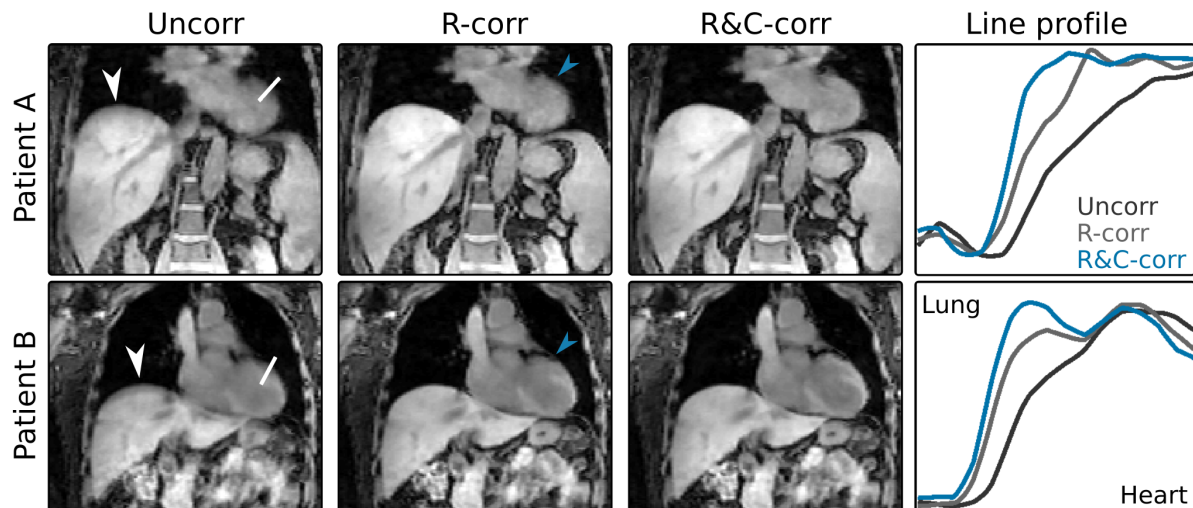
3D GRPE MR images reconstructed without motion correction (Uncorr), with respiratory motion correction (R-corr) and with respiratory and cardiac motion correction (R&C-corr) for two patients. Line profiles taken from the top of the heart (location marked with white line in Uncorr) for all three images are also shown.
